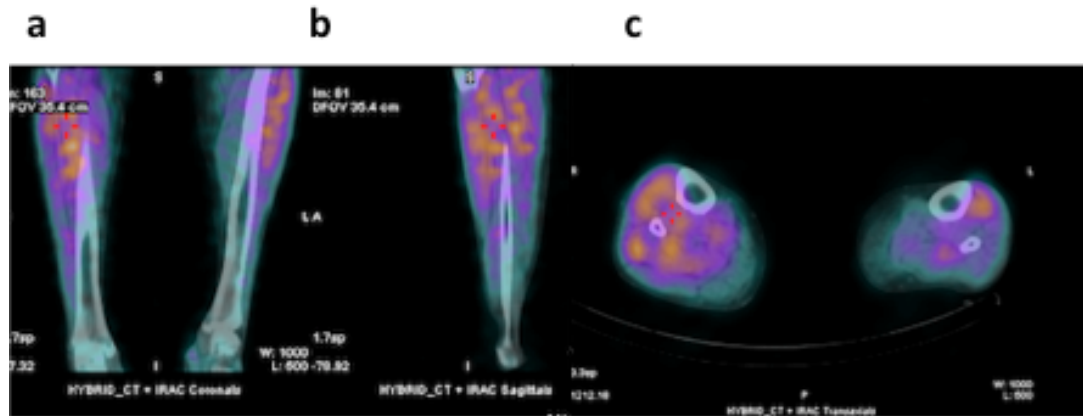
Hybrid SPECT/CT cross-sectional images of the calves of Patient E at rest. Panel a (coronal section), b (sagittal section), and c (axial section).
